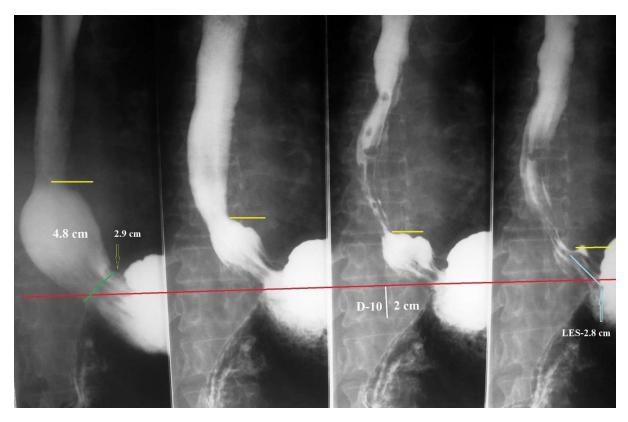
Sequential radiographs while drinking barium in a patient with GERD and esophagitis. At first, the ampoule with a diameter of 4.8 cm was filled. The diameter of the hiatus channel (green) is 2.9 cm. It is unlikely that the contraction of the CD can exert pressure on the EGJ with such a wide diameter of the hiatus channel. The size of the ampoule gradually decreases due to the approach of its upper edge to the stomach. This indicates peristalsis, which excludes HH since there can be no peristalsis in the fundus of the stomach because there are no Cajal cells in it. In the process of emptying the ampulla, the stomach is in the same place (the red line is drawn along the upper edges D-10). Longitudinal folds are defined along the entire length of the esophagus and at the level of the LES. The length of the LES is approximately 2.8 cm. After emptying the ampulla, no slip of the stomach into the chest is observed.
